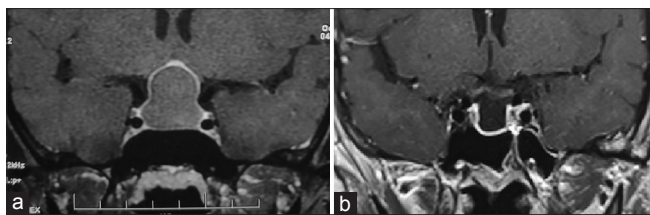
Pre-operative MR imaging of sella showing pituitary abscess (a) and post-operative MR imaging of sella showing partial empty sella (b)
